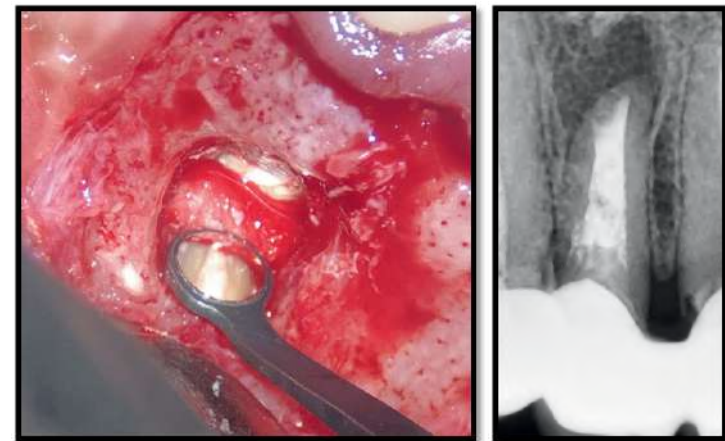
Hermetic seal provided by CeraPutty and CeraSeal Bioceramics materials combination confirmed clinically and radiographically.
